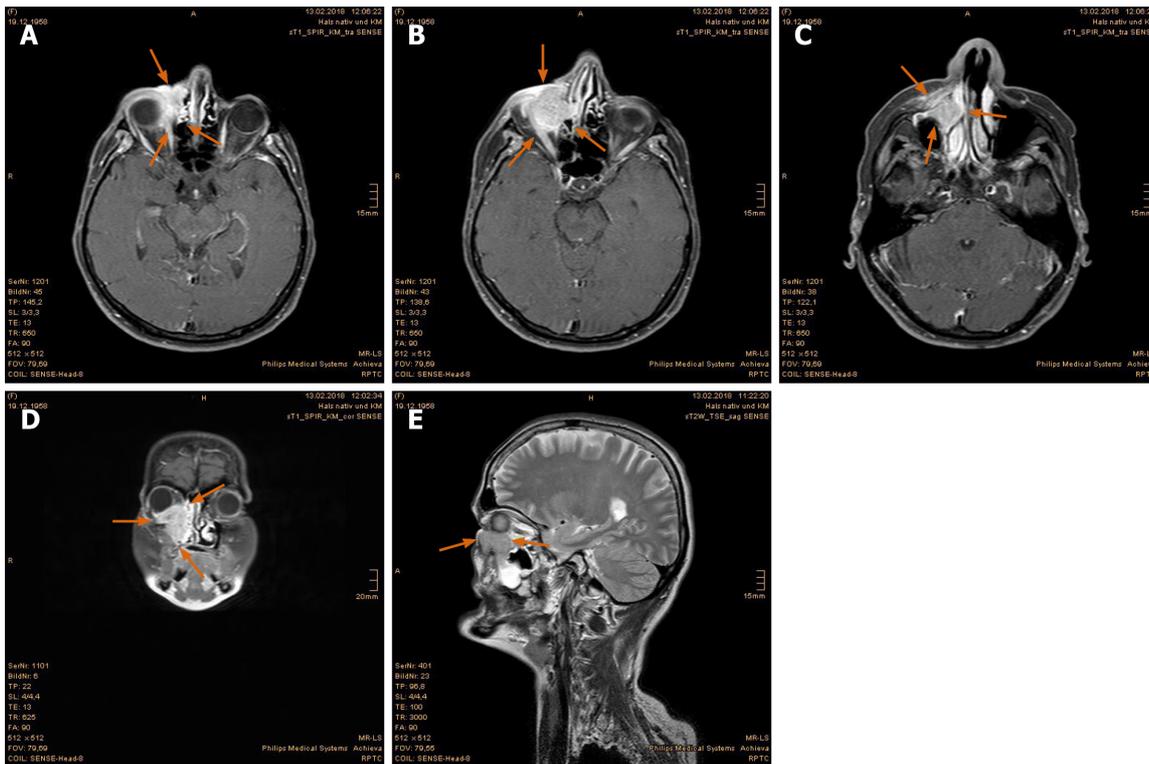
Magnetic resonance imaging prior to proton beam therapy. A: Naso-orbital nodular enhancement with lacking delimitation to the right eyeball; B: Tumor displacement of the right eye; C: Growing tumor invasion of the right maxillary sinus, turbinates and adjoining facial soft tissue; D: Coronal presentation of the right periorbital sinonasal cancer; E: Sagittal presentation of the sinonasal cancer with shift of the right eyeball upwards. Tumor marked with arrows.
